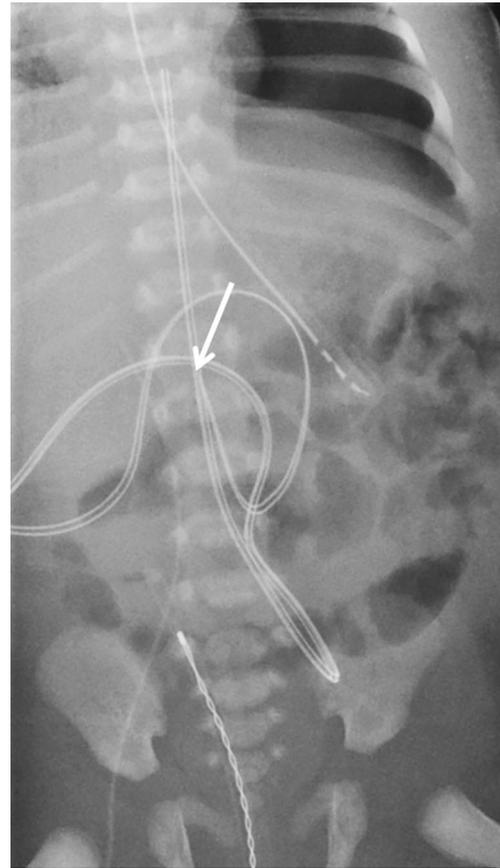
Anteroposterior radiograph of the abdomen in a 4-day-old girl. The radiology report excerpt was as follows: “There is a right femoral line with the tip in the IVC at the level of L1. The patient has an umbilical artery line with the tip at the level of T8. Feeding tube is in the stomach. Bowel gas and is normal (*sic*). There is a left pneumothorax, not completely imaged.” There was no mention of the suboptimal location of the UVC (umbilical venous catheter) in the radiology report, although it is seen overlying the umbilical vein (*arrow*). *IVC* inferior vena cava
